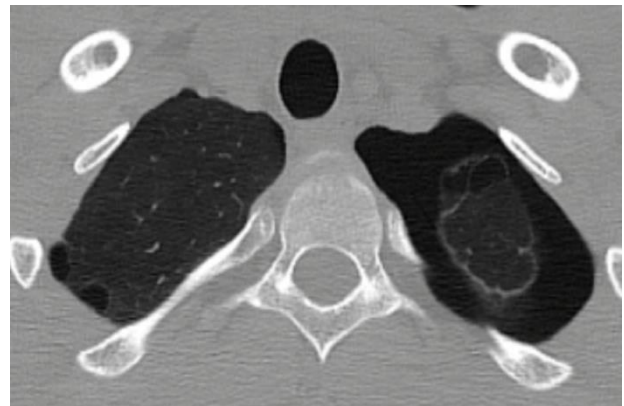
Axial CT image showing multiple bilateral apical bullae with Lt pneumothorax.
